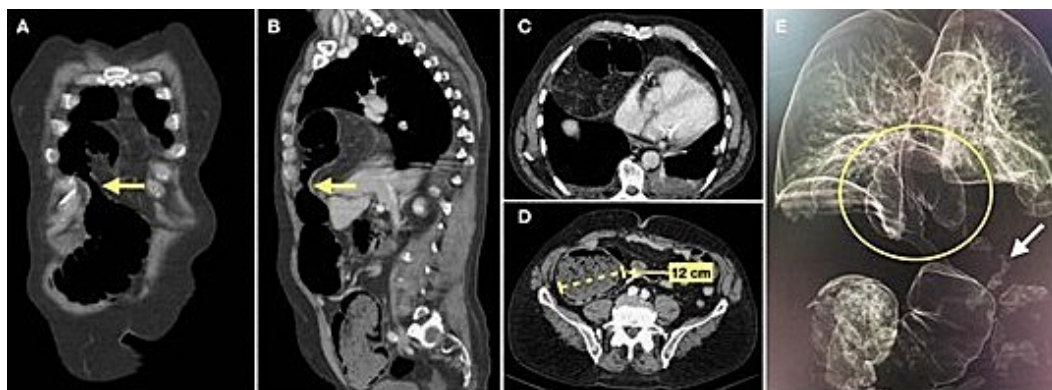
CT scan. Coronal (A) and sagittal (B) images demonstrate the site of incarceration (arrow). Axial images (C and D) show colonic dilation with a maximum cecum diameter of 12 cm. Three-dimensional reconstruction (E) depicts the point of incarceration (circle) and the absence of distal colonic distension (arrow).
